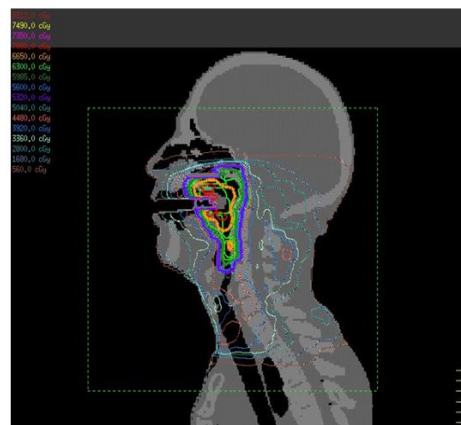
Dose distribution on 3 density class CT scan. Bone appears in white, soft tissue in grey and air in black. CT scan imaging is hidden.
